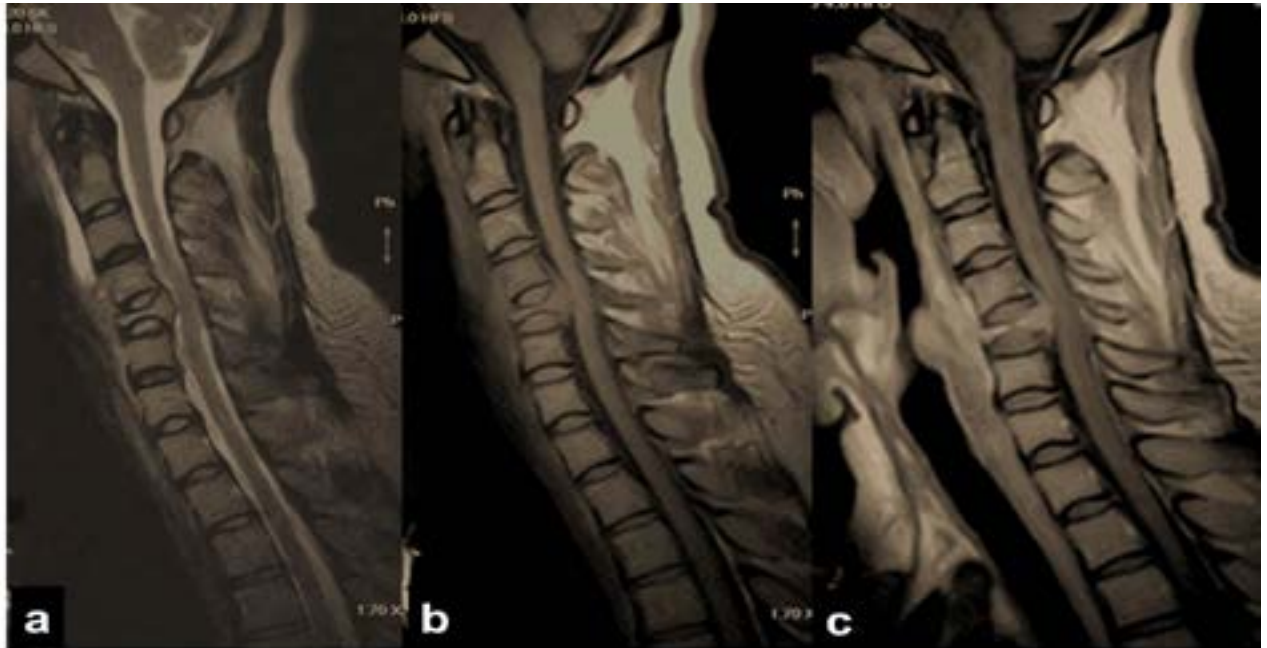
Sagittal MRI of Cervical spine - (a) T2, (b) T1, (c) Post IV Gad, demonstrating the collapsed C5 vertebra with obliteration of the anterior theca sac and compression onto the spinal cord by an enhancing soft tissue mass at that level
